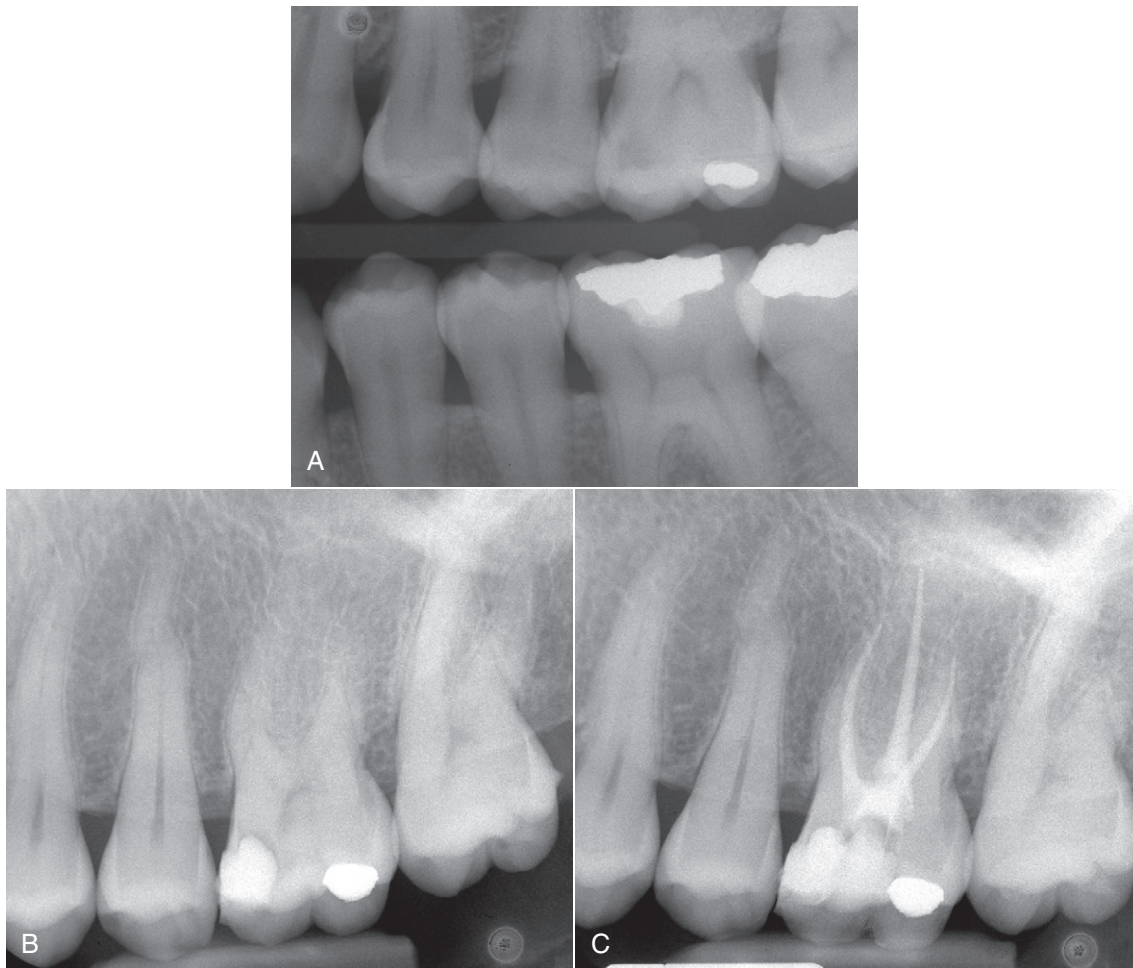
Combined restorative-endodontic case. A, Asymptomatic first upper left molar with radiographic mesial carious lesion. B, Preliminary temporary restoration. Endodontic treatment was decided because of caries depth. C, Finished endodontic treatment. (Courtesy of Dr Carlos Bóveda.)
